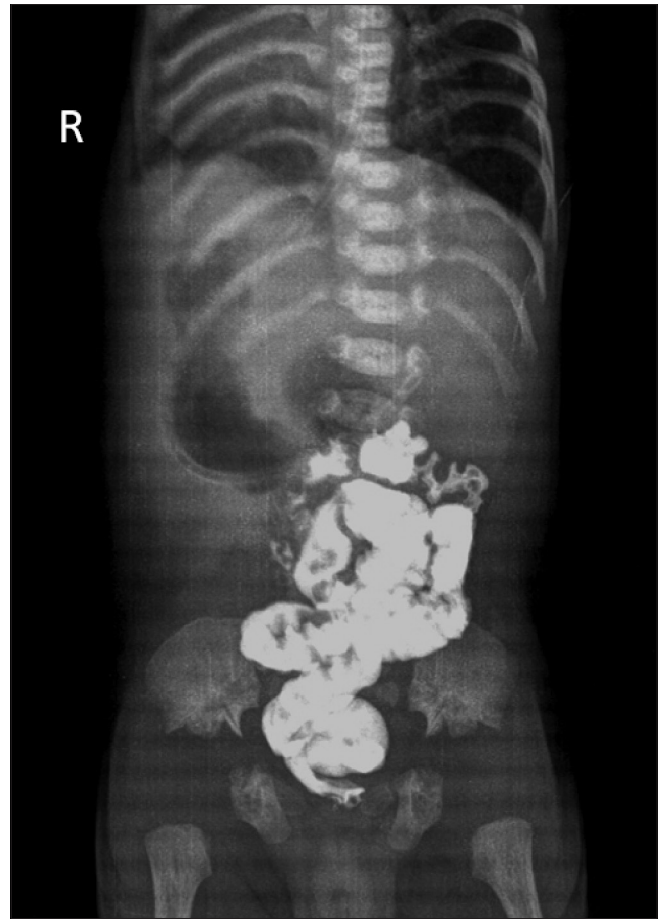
Delayed radiograph obtained 24 h after contrast administration shows large bowel loops appear to be located entirely in the midline of the abdomen
